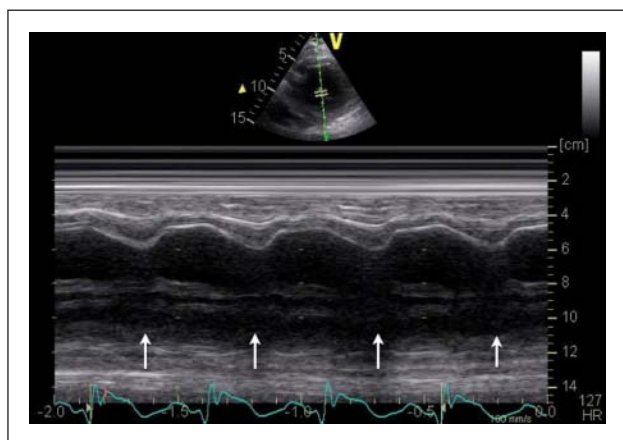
M-mode interrogation of a transthoracic echocardiography short-axis view
